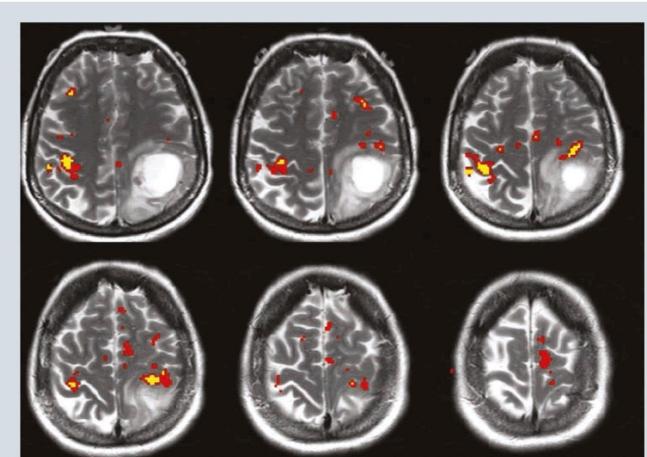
Patient with a left parietal glioblastoma. The patient's motor function was significantly compromised, which precluded the use of an active motor paradigm. Nevertheless, the location of the precentral (motor) gyrus could be deduced using a passive sensory functional MRI paradigm, which did not include any activity by the patient.
